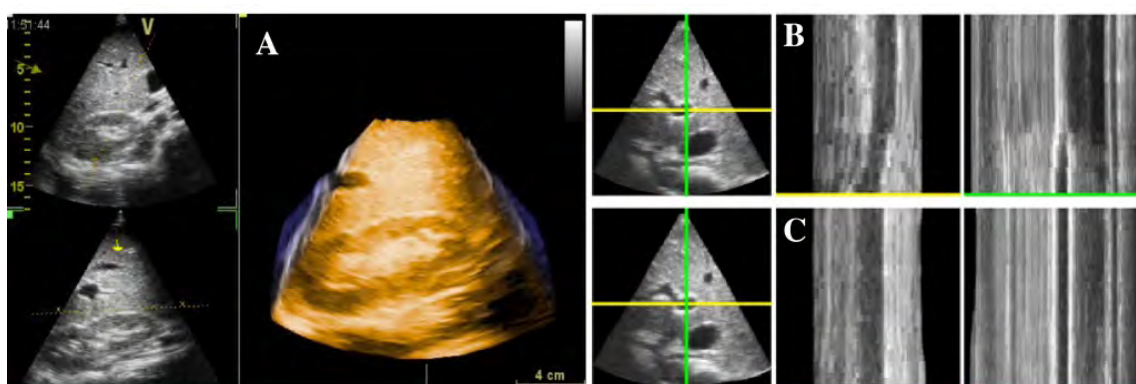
A) 4D (3D+t) Ultrasound of the liver. Example image before (top row B) and after (bottom row C) registration. The middle (B-C) and right panel, respectively, show the evolution over time (vertical axis) of the horizontal and vertical profile indicated by the cross in the left panel. After registration, the motion has been successfully removed from the image (straight vertical lines).
